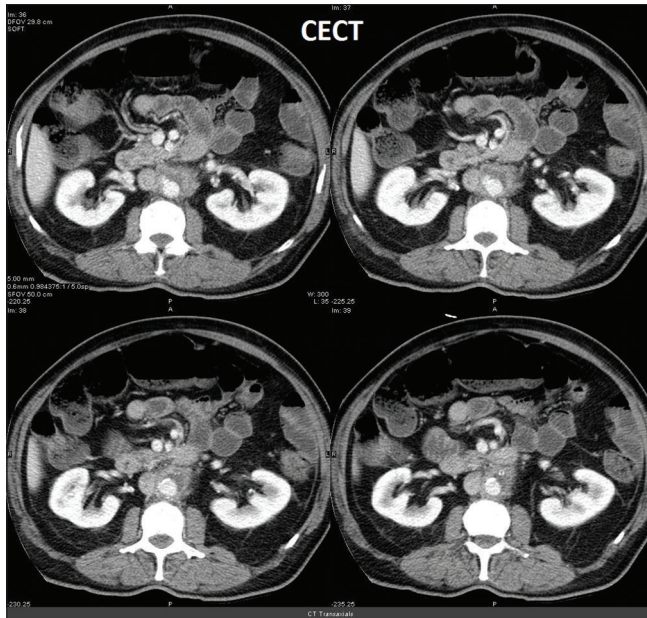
Contrast-enhanced computed tomography abdomen showing saccular aneurysm involving infra renal aorta (diameter of 1 cm), and peri-aortic soft tissue with central necrosis extending proximally and distally to aneurysm, encasing origin of inferior mesenteric artery
